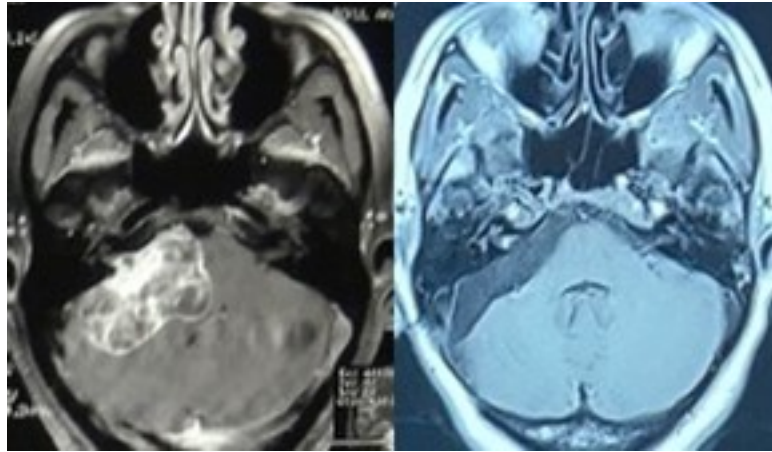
Preoperative and postoperative MRI of a patient with right-sided acoustic schwannoma.
